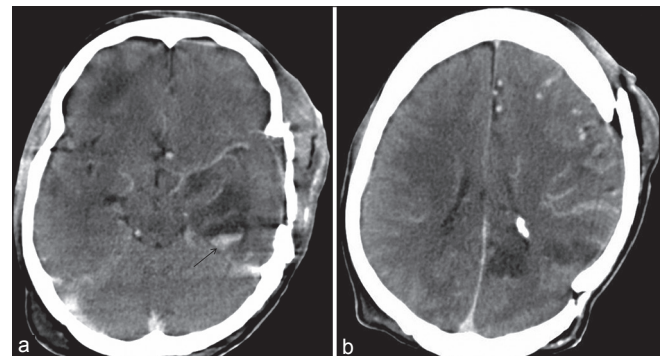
(a) Postop contrast-enhanced CT showing resolution of midline shift, persisting edema. There are multiple deep temporal infarcts with a small area of hemorrhage in one of the infarcts (arrow). (b) computed tomography showing infarcts in the left middle cerebral artery and anterior cerebral artery territory
